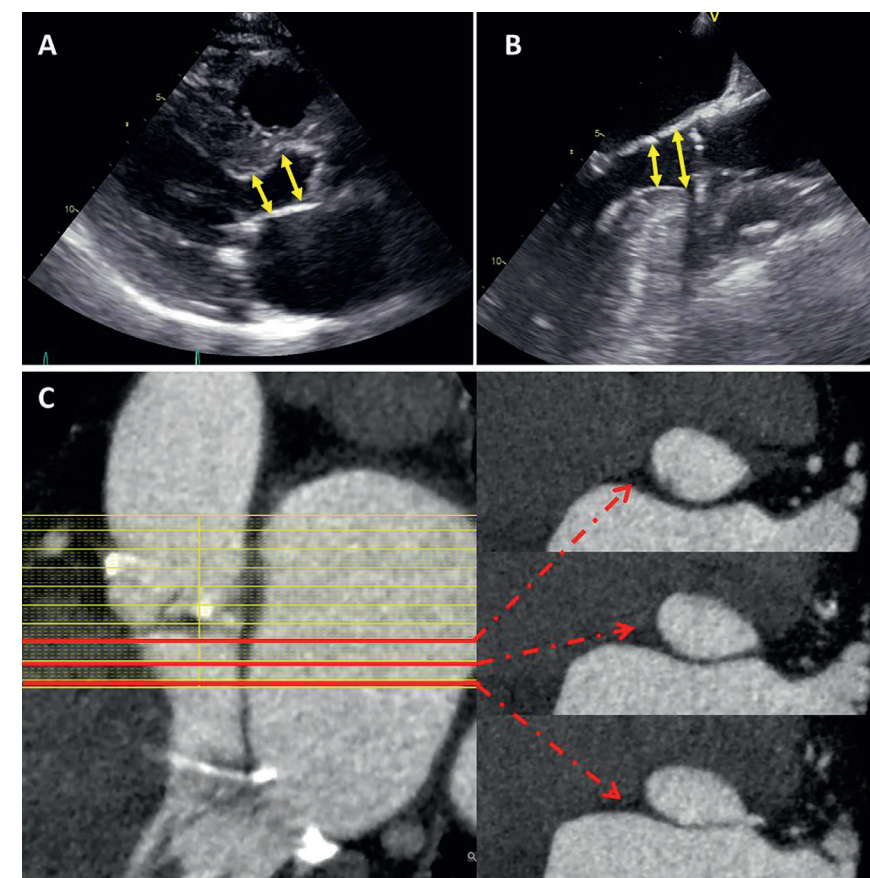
Assessment of left ventricular outflow tract (LVOT) with transthoracic (A) and transesophageal (B) echocardiography and multidetector row computed tomography (C). On 2-dimensional transthoracic and transesophageal echocardiography the measurement of the LVOT may vary significantly (arrows), particularly in patients with sigmoid septum, having important implications on aortic valve area calculation. On MDCT, the cross-sectional area of the LVOT at each level shows the increase of the elliptical shape for the aortic annulus toward the left ventricle. Red lines depict LVOT areas at 3 different levels showing the change in area and ellipticity of the LVOT.
